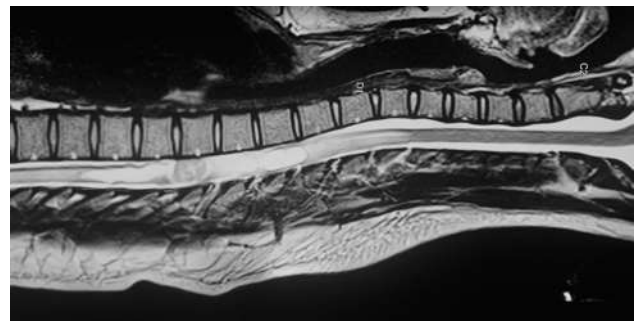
Preoperative MRI of the dorsal spine: T2-weighted images showing the intramedullary lesion and cord expansion with syrinx formation.
